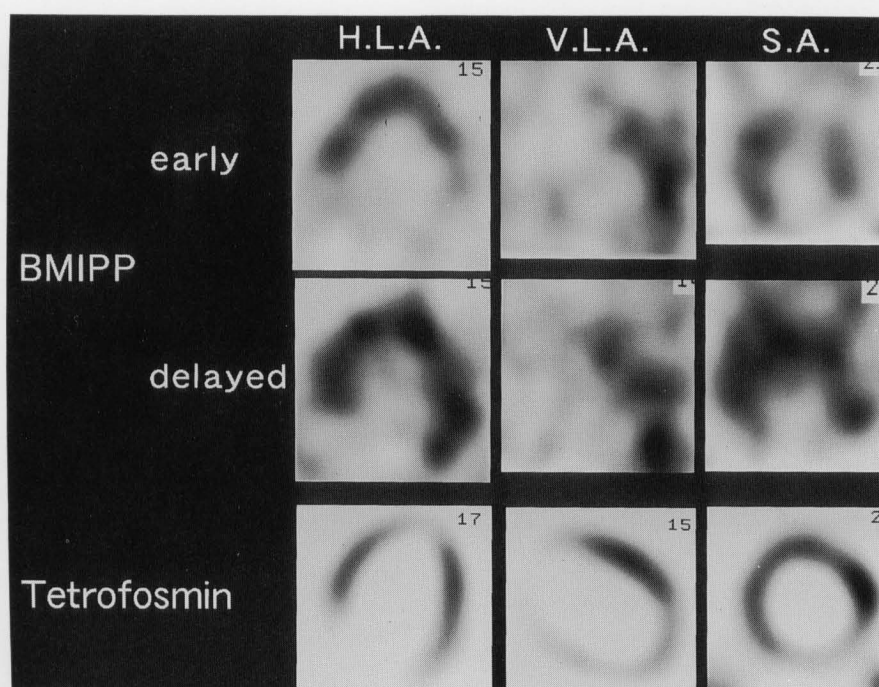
^{123}I -BMIPP and $^{99\text{m}}\text{Tc}$ -tetrofosmin myocardial SPECT images on the tenth hospital day in 1999. Both early and delayed ^{123}I -BMIPP images show myocardial uptake. $^{99\text{m}}\text{Tc}$ -tetrofosmin images obtained immediately after ^{123}I -BMIPP imaging show myocardial uptake similar to that of ^{123}I -BMIPP images.
